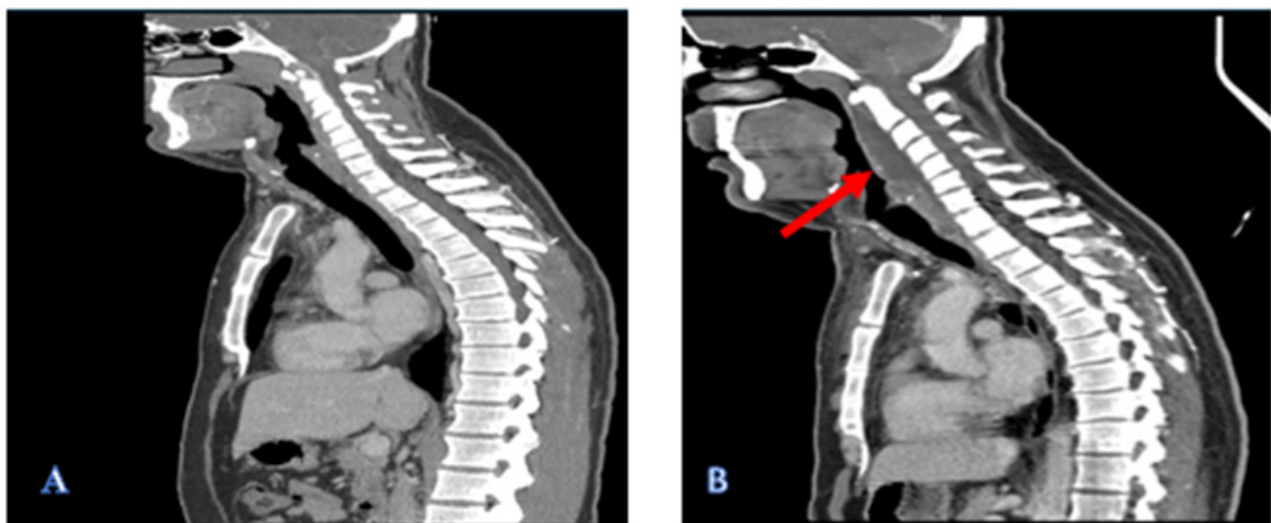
A: Thrombus in the subclavian vein as shown in the Computed Tomography of the Thorax. B: Thrombus that extended to the subclavian vein and filled the lumen in the superior vena cava vein as shown in the Computed Tomography of the Thorax
